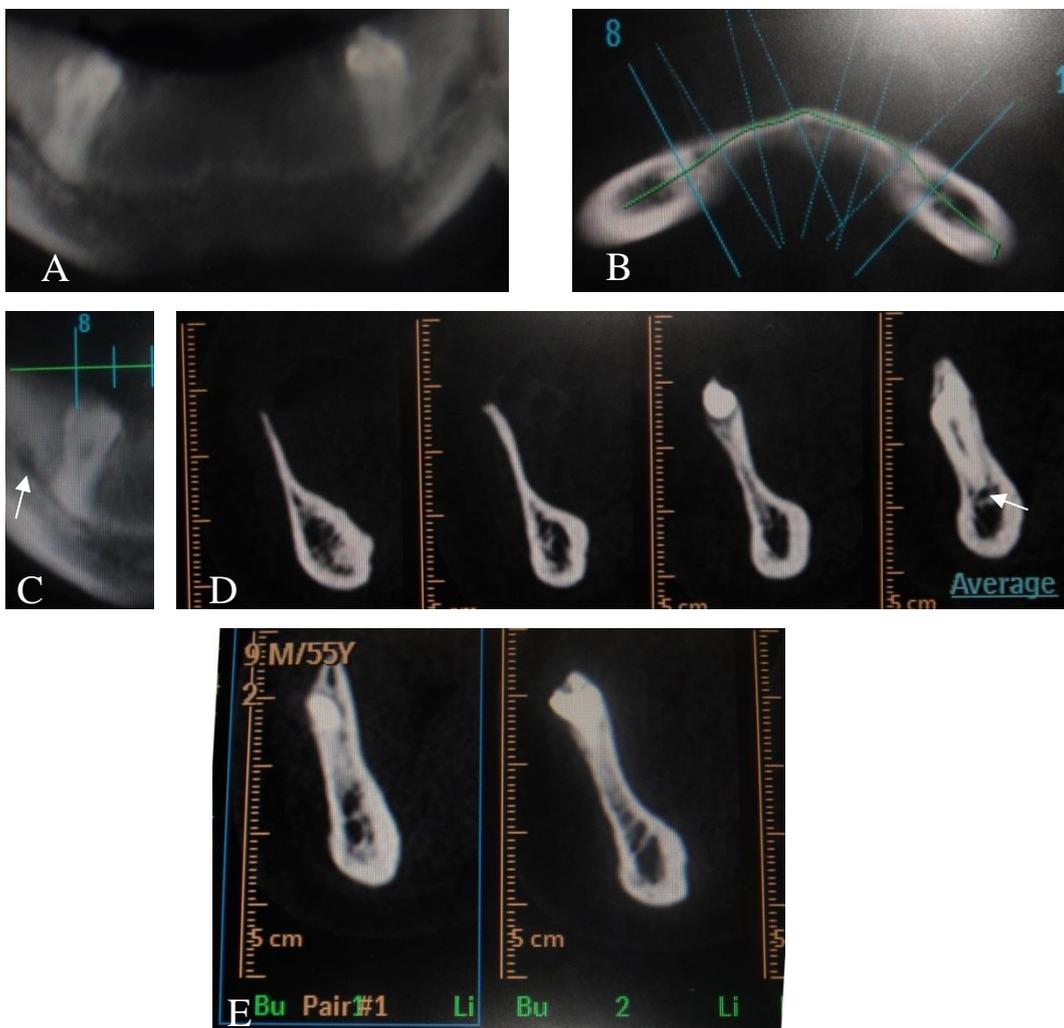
Dental Software CT views of mandible for patient with 50 years old with the complete impacted left premolar A. axial slice of mandible; B. axial slice with planning lines; C. panoramic section shows the apex of lower right impacted premolar within the mandibular canal (white arrow); D and E. multiple cross sections sagittal views of left and right of the impacted premolar teeth respectively, the mandibular canal is visible as a small cortical ring (white arrow).
